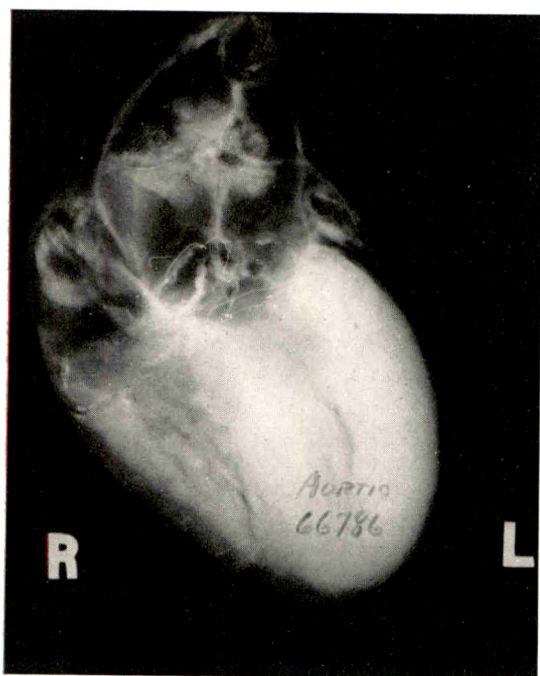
Roentgenogram of heart post mortem. Upper left wire at attachments of aortic valve, calcification in valve leaflets, in bead-like strings (Case XI). Also slight calcification in mitral valve and in coronary arteries. Note that ventricles form most of heart shadow, compared to Figure 11, where auricles predominate.
